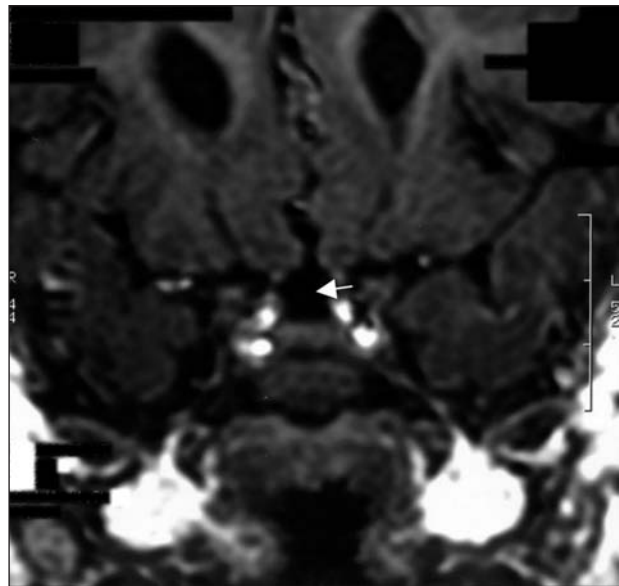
MRI showing agenesis of the pituitary stalk on T1-weighted coronal cut.
